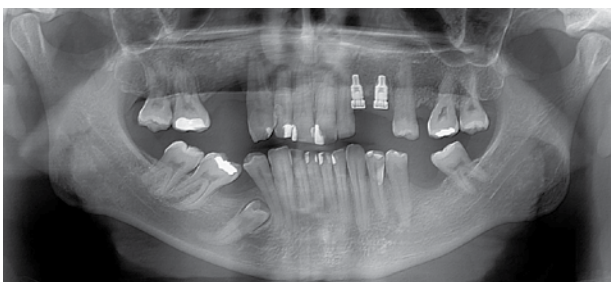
Radiographic aspect after six months of enucleation
